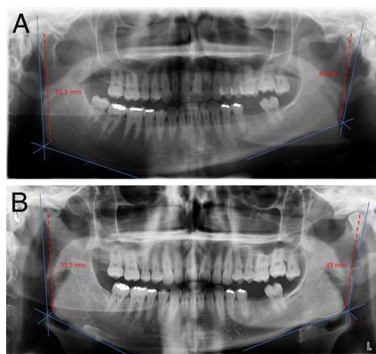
A patient with right hemimandibular hyperplasia. Measurement of the height of the condyle-ramus unit on the panoramic radiograph preoperatively (A) and postoperatively (B).
